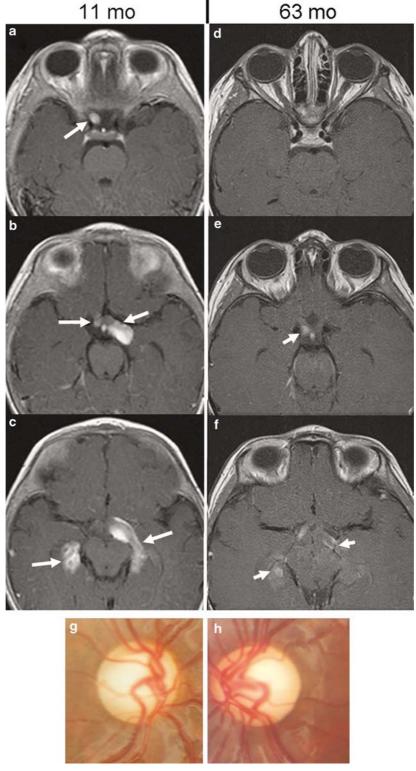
(a–f) T1-weighted post-contrast axial orbit MR images of patient #3 at 11 months of age (a–c) and at 63 months of age (d–f). Images show glioma involving the intracranial optic nerve on the right (a, arrow), chiasm (b, arrows), and optic radiations bilaterally (c, arrows). (d–f) Images obtained after treatment with chemotherapy reveal marked reduction in enhancement of the tumour. Glioma involvement of the chiasm and optic radiations is still evident (short arrows). (g, h) Right (g) and left (h) optic disc photographs of patient #3 obtained at 5 years of age show deep central cups with central pallor, and intact rims.
